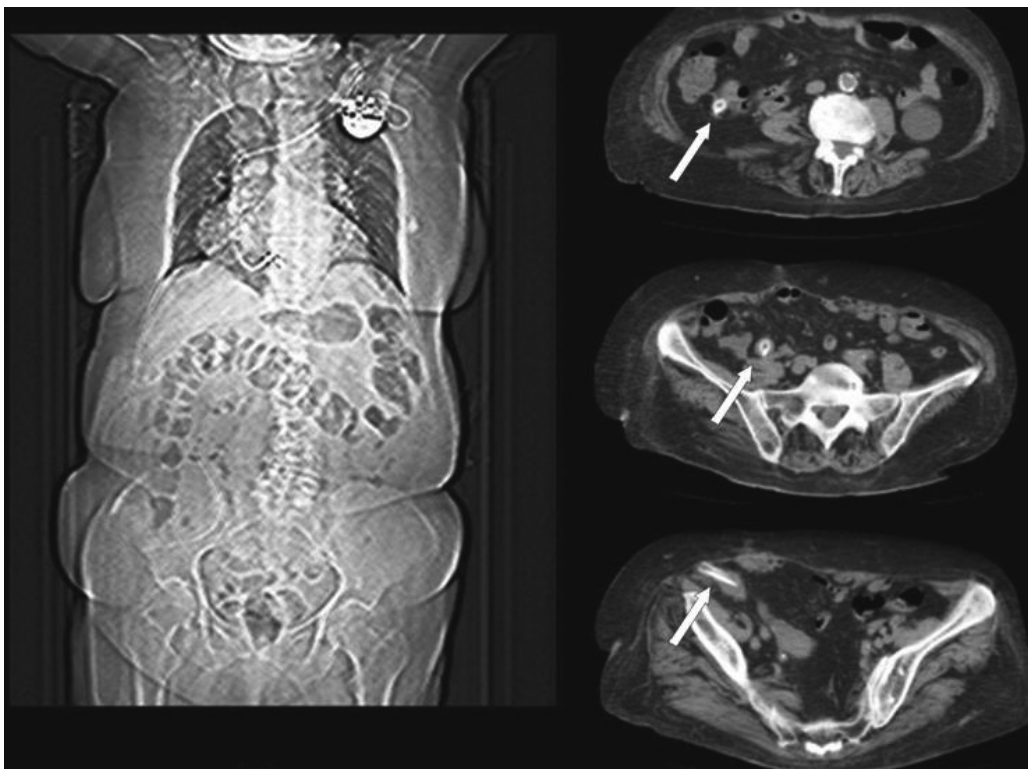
Presence of an intra-peritoneal foreign body at CT-scan.
